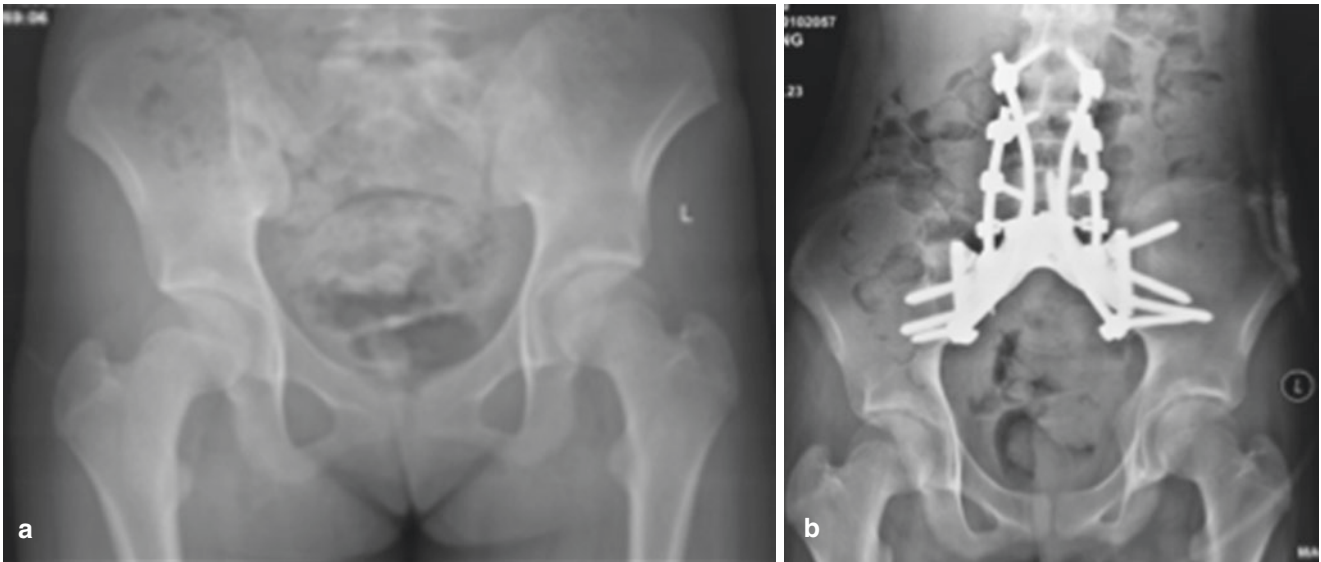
(a) Preoperative plain film of a 14-year-old female patient with sacral osteosarcoma. (b) Postoperative plain film of the reconstruction with a sacral prosthesis
